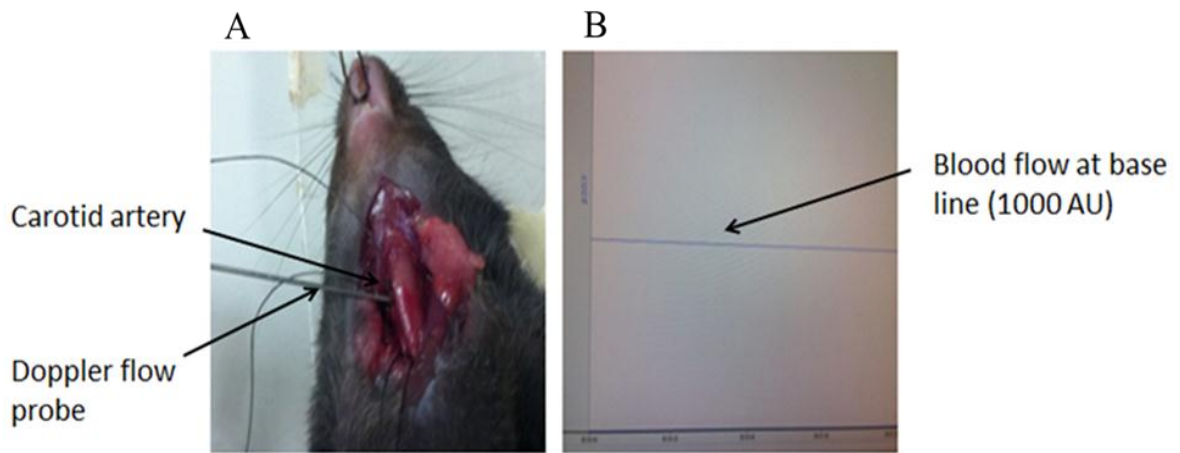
Surgical preparation for ferric chloride induced thrombus formation: A) positioning of a Doppler flow probe proximal to the carotid artery and B) Measuring the baseline blood flow before thrombus initiation (baseline blood flow 1000 arbitrary unites (AU)).
